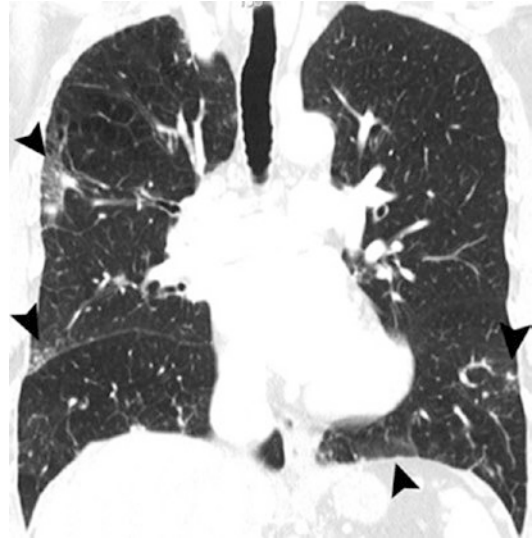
63-year-old man with organizing pneumonia (OP). The patient was receiving amiodarone for cardiac arrhythmia. Coronal CT image shows bilateral areas of ground-glass opacities in subpleural distribution (*arrowheads*)
